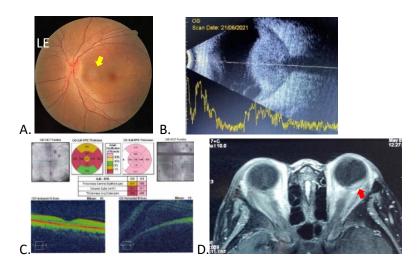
The Clinical condition of 5-month follow-up of left eye. A. Fundus photograph showed optic nerve head edema with hyperpigmentation which extends to macula (arrow) B.B-Scan Ultrasound showed scleral thickening and fluid accumulation in subtenon space. C. Macular OCT showed increased subretinal fluid in the left eye. D. Orbital MRI showed scleral thickening with T-sign (arrow)
